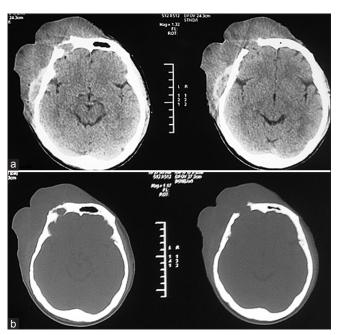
(a) CT scan imaging showing infiltrating mass at the frontal region. (b) CT scan reveal bone discontinuity due to bony destruction
